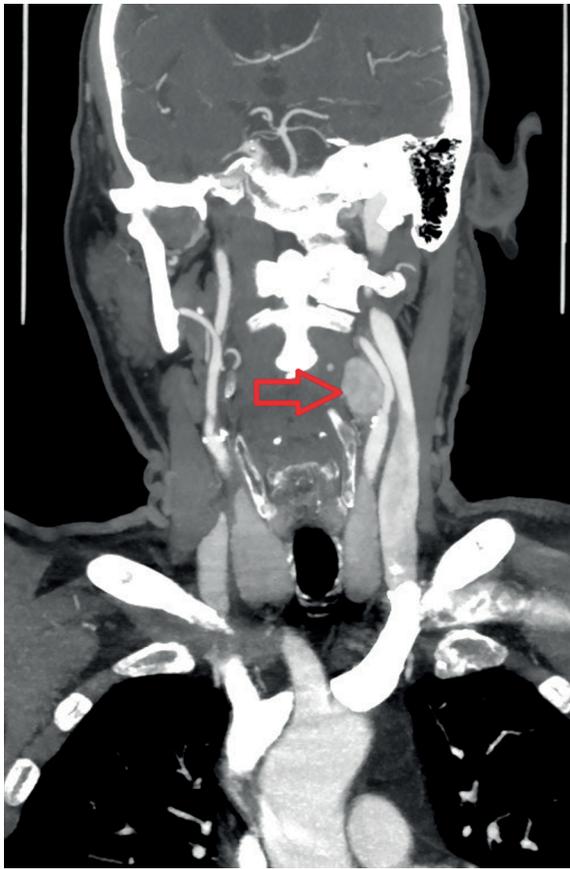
Coronal MR imaging of chemodectoma.
